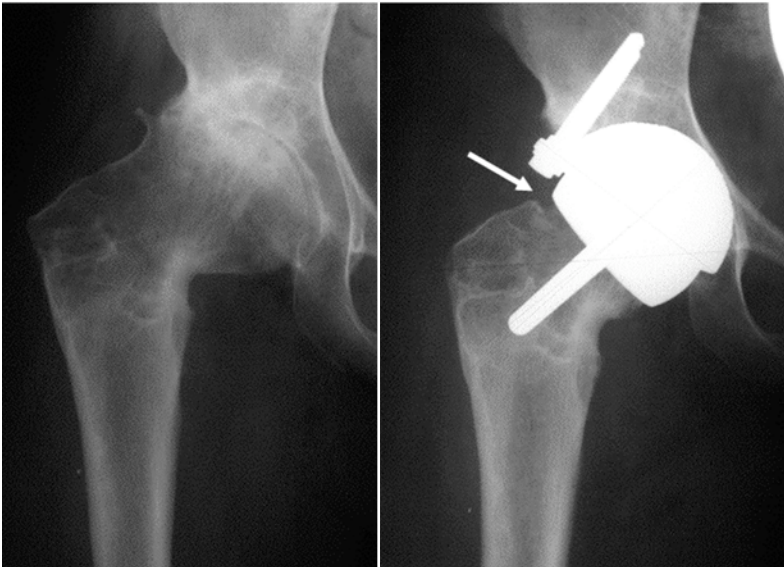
Pre- and postoperative radiographs showing a notching of the lateral femoral neck.
